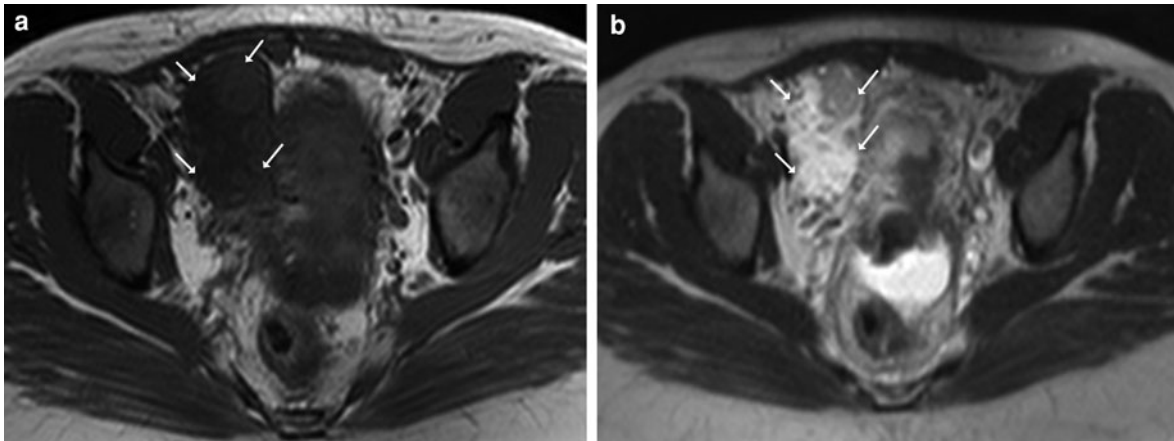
Adnexal torsion in an 18-year-old pregnant woman. Axial T1-weighted gradient-echo image (a) shows enlarged, hypointense right adnexa (arrows) containing multiple peripherally located follicles. The right enlarged adnexa (arrows) has
